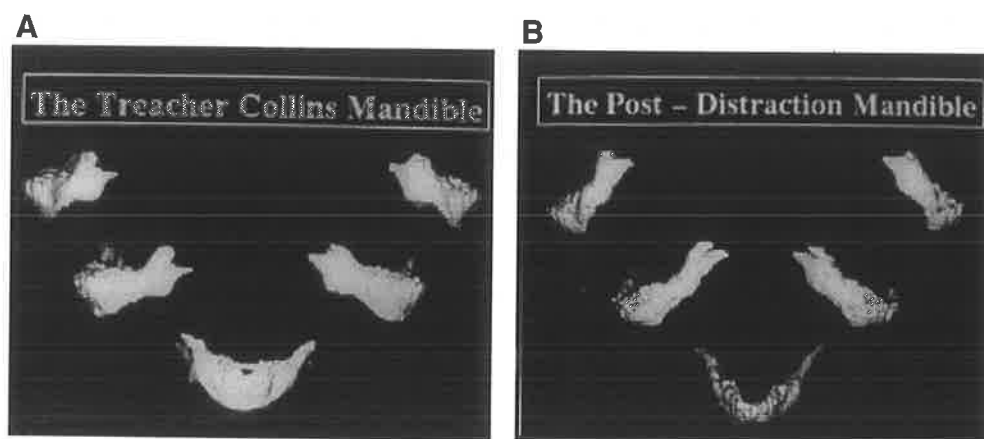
A. Preoperative three-dimensional computed tomography (CT) reconstructions of the mandible in this case. B. Postoperative three-dimensional CT reconstruction of the mandible identifies the lengthening primarily in the ascending ramus, with greater length achieved on the left side.
